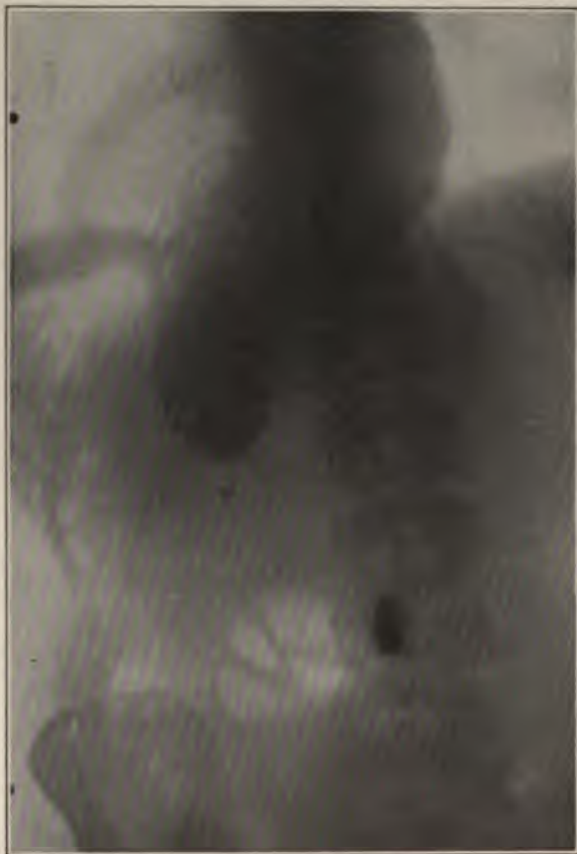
REMARKABLE OBSTRUCTIVE DILATATION OF ESOPHAGUS. The organ retained 30 ounces of bismuth milk suspension for over 2 hours. It would empty into stomach only after ingestion of an additional quart of fluid. (This is one of a series of roentgenograms Dr. G. H. Stover.)
